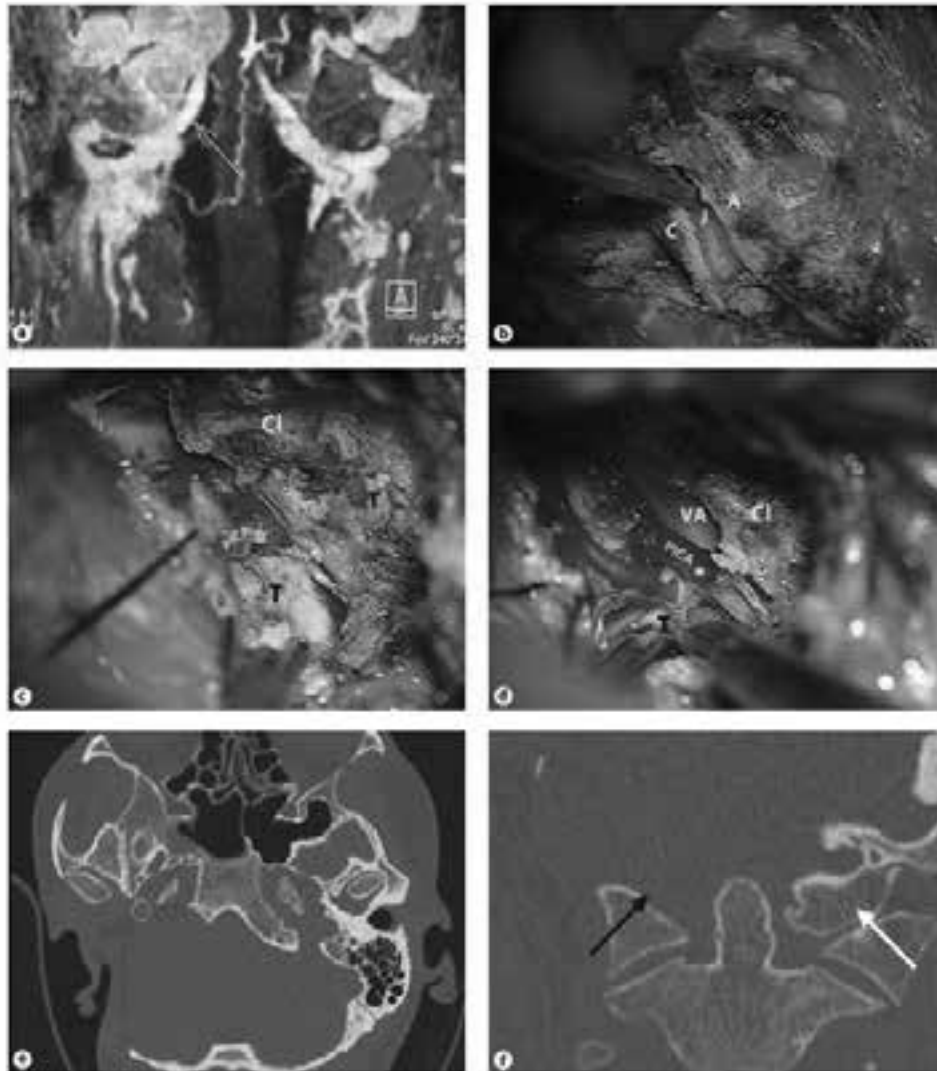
A - A class C4Di2Vi tumour. MRI coronal image demonstrating tumour encasement of the VA. B-F – Surgical steps of extreme lateral approach. B - The transverse process of the atlas (A) is drilled out and the atlanto-occipital joint (J) is removed. C = Condyle. C - The tumour (T) is attached to the vertebral and posterior inferior cerebellar arteries infiltrating the clival (Cl) bone, which is partially drilled out. D - The tumour is separated from the PICA. E - CT scan. Axial view showing the stent in the ICA and the extent of bone removal. F - CT scan coronal view showing resection of occipital condyle (black arrow) compared to non-operated side (white arrow).
